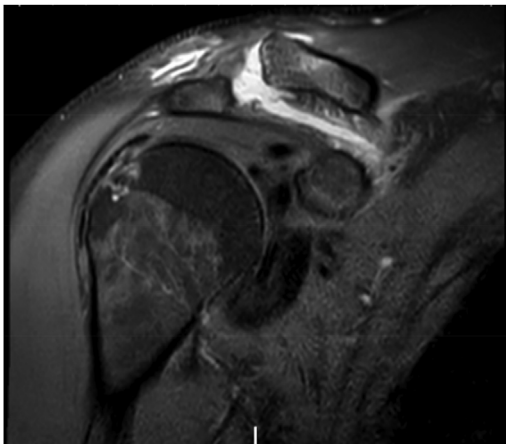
Coronal MRI of R shoulder demonstrating a complete disruption of the superior and inferior AC joint capsule and coracoclavicular ligaments (type III).
